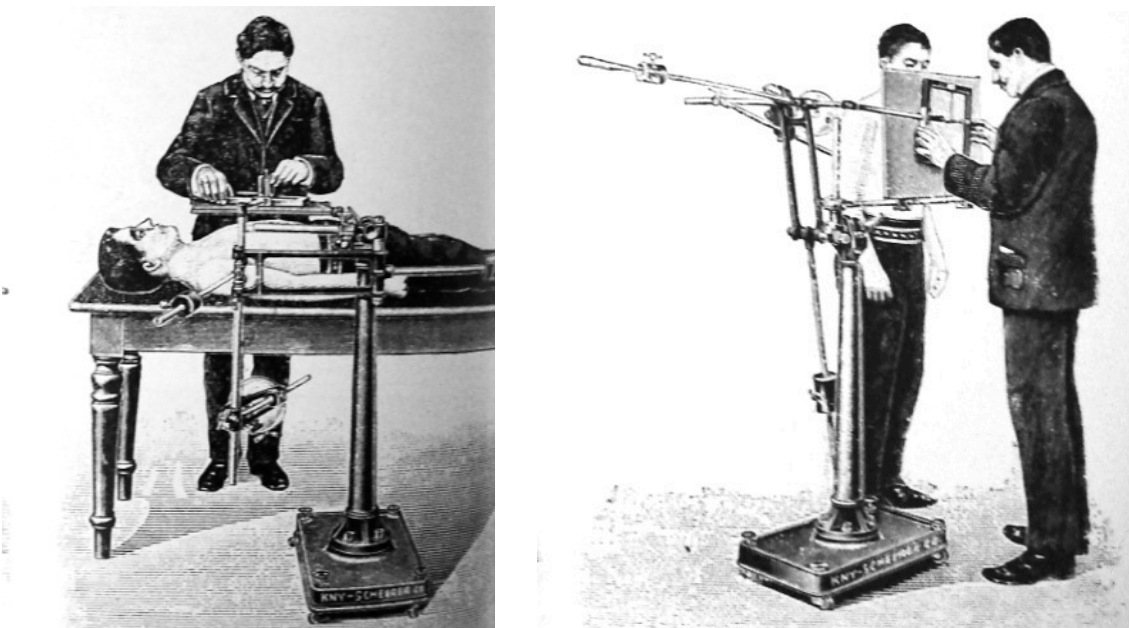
Diagnostic X-Rays c.1905.⁴⁹⁹
